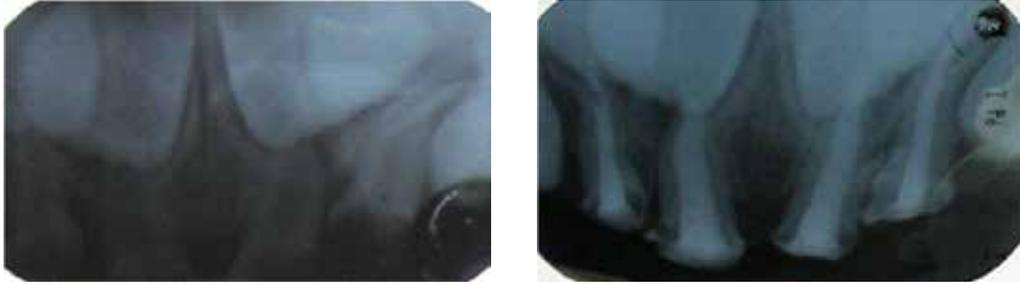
Pre-operative and postoperative radiographs of maxillary incisors
